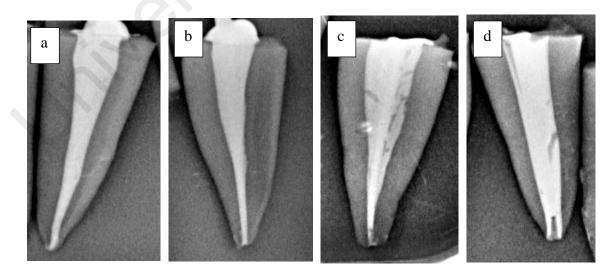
Example of included and excluded teeth after obturation. a and b show mesiodistal and buccal lingual periapical views of included sample. c and d show mesiodistal and buccolingual periapical views of excluded sample.
